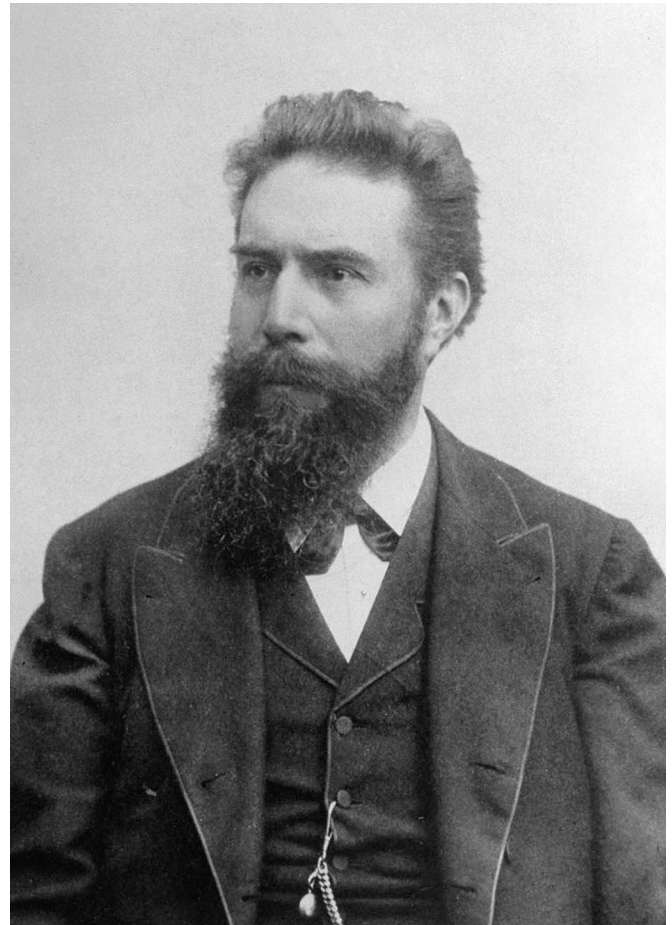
W.K. Roentgen (1845–1923). He discovered x-rays on November 8, 1895.
